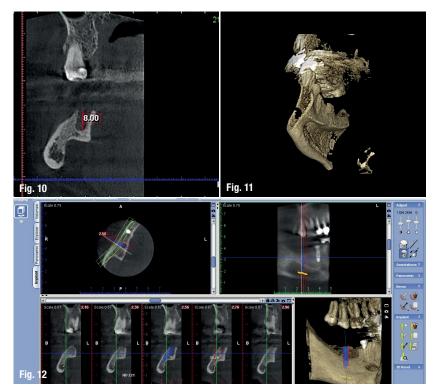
Axial CBCT slice demonstrates the height of the extraction socket is 8 mm
